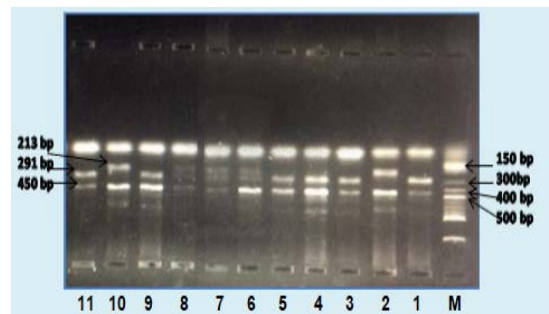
Genotyping of *FTO* gene polymorphism (rs1421085) by Tetra-ARMS PCR on 2% agarose gel electrophoresis. Lanes M: DNA Marker. Lanes 1,3, 4,5, 9 and 11: CC genotype. Lanes: 2 and 10: TT genotype. Lanes, 6,7 and 8: CT genotype.
